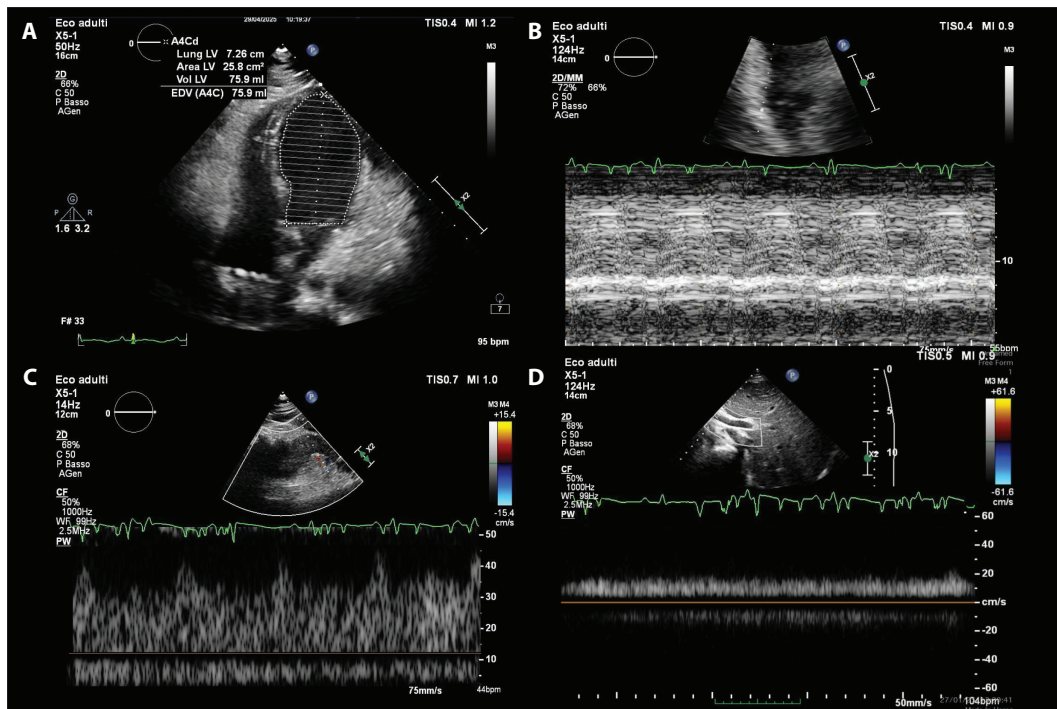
The ultrasound examination after the V-A cannulation. a) the left ventricular end diastolic volume with the ventricular shape recalling the apical ballooning phenotype. b) TAPSE (8 mm) with V-A ECMO flow 3.8 L/Min. c) Doppler kidney ultrasound with low resistive index and continuous venous Doppler flow and d) portal vein continuous pattern.
